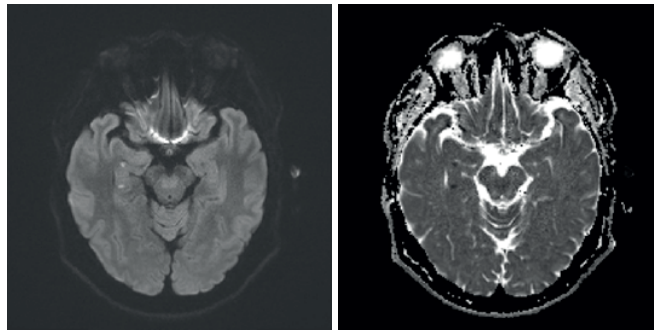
Brain DWI of the patient. Two dot-like high signal intensities with diffusion restriction were observed in the right hippocampus.
